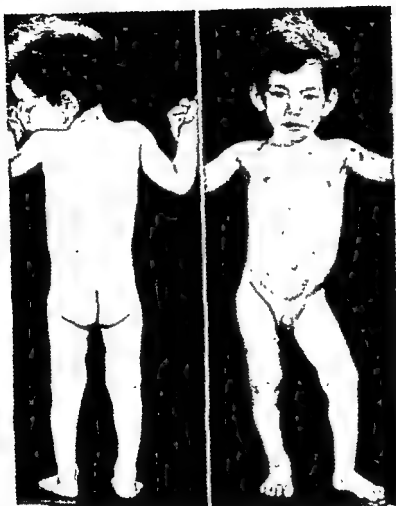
Two years and three months old boy seen because of weakness of legs. Examination also revealed abdominal mass. Photographs show patient after removal of extradural tumor at laminectomy and retroperitoneal abdominal tumor locally and at laparotomy. Patient alive two years after this surgery and x-ray therapy.
